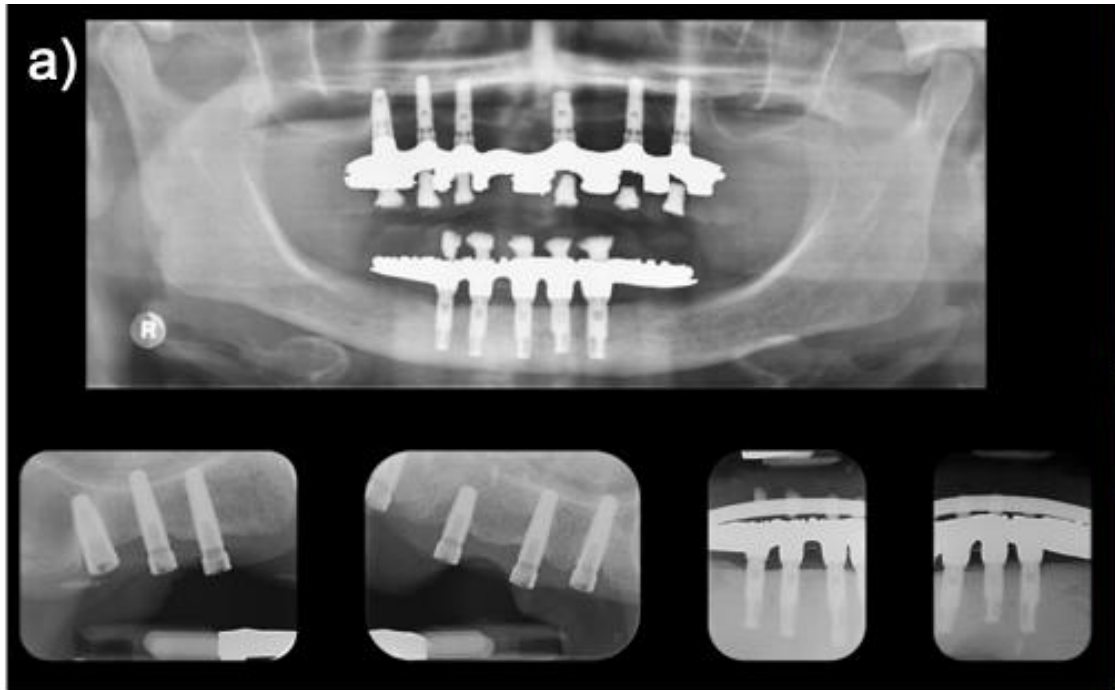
Full-arch peri-implantitis case. a) Panoramic and apical x-rays showing bone loss in upper implants; b,c) Initial clinical appearance of soft tissues, upper and lower; d, e) Soft tissue improvement after non-surgical treatment, upper and lower. Case treated in the Implant Maintenance Unit of the Master degree program in Oral Surgery and Implantology of the Universitat de Barcelona.
